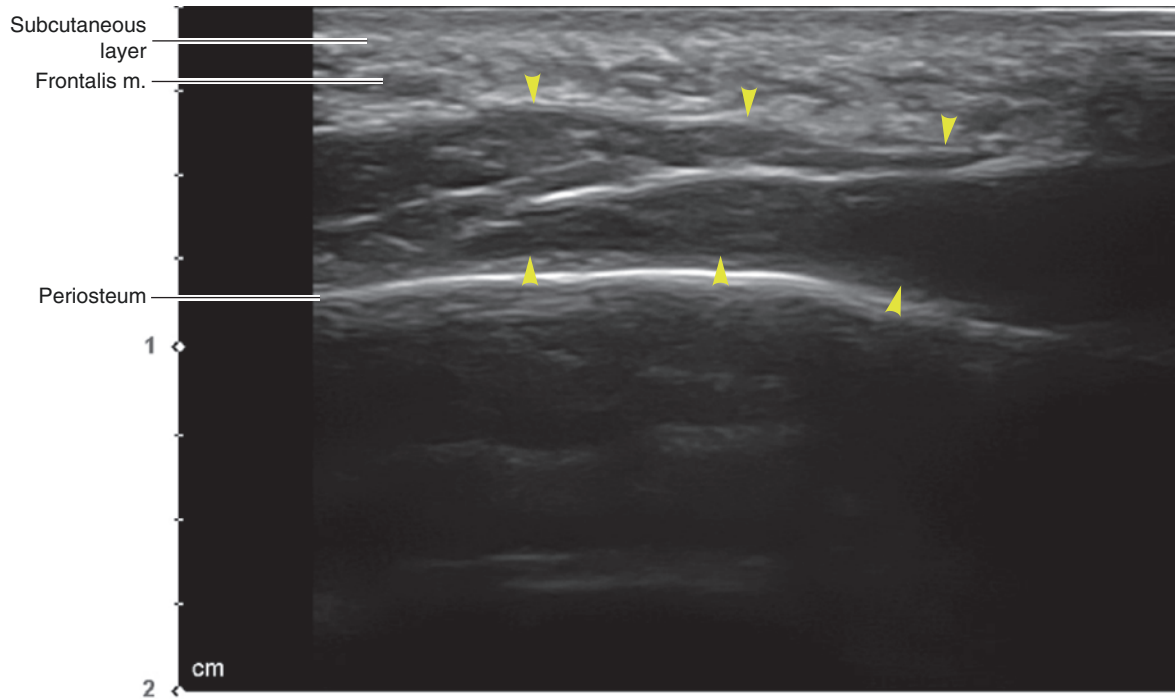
Ultrasonography of the HA filler for the forehead augmentation, B mode (transverse view, 15 MHz by linear transducer) (yellow arrowheads: HA filler). (Published with kind permission of © Ji-Soo Kim 2020. All Rights Reserved)
